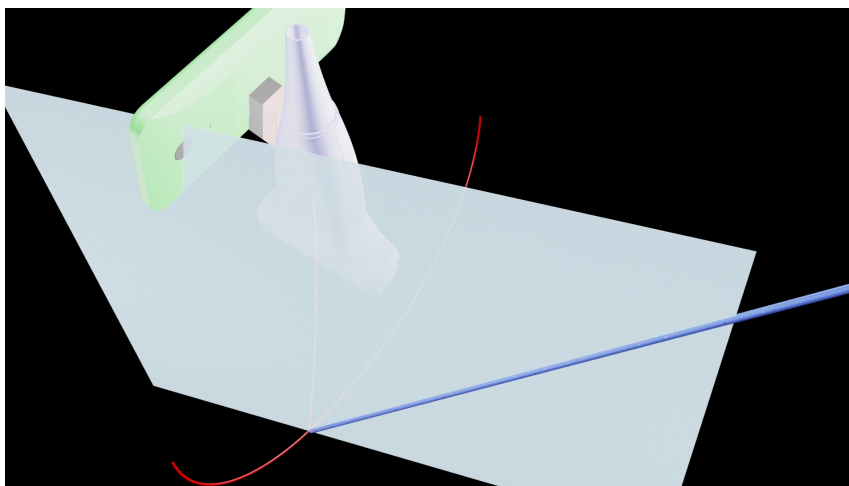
The graphical description of fusing the sensor information from the camera and piezoelectric element. The plane obtained from the camera and the arc obtained from the ultrasound are geometrically intersected to determine the location of the needle tip.
